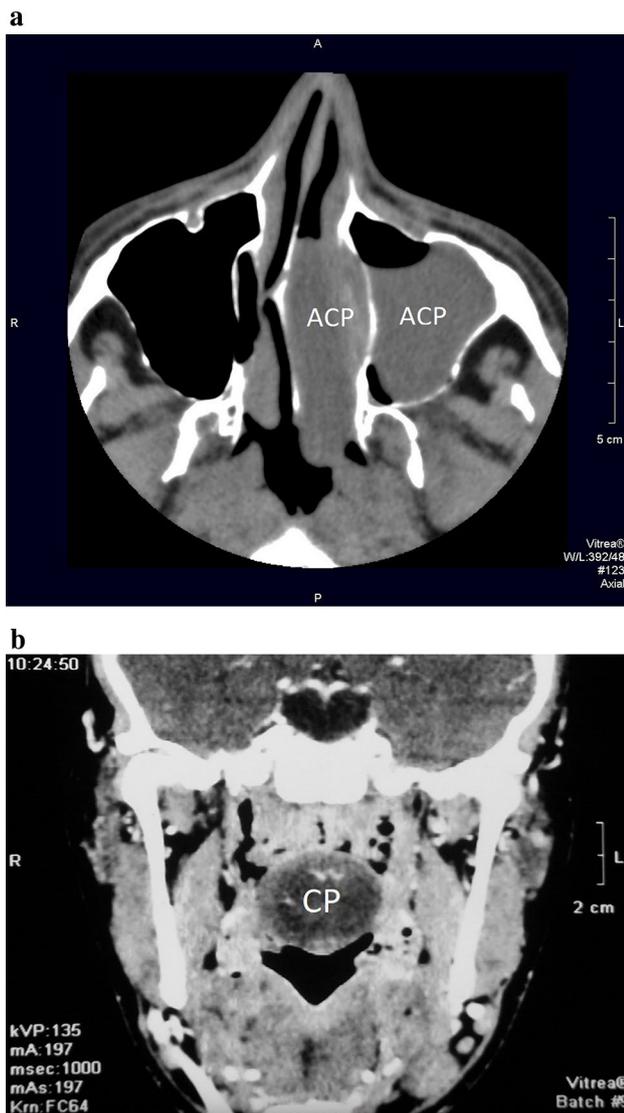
a Axial plane of CT scan of the paranasal sinuses in a 15-year-old boy with ACP. Note the presence of an antral and a nasal portion of the same polyp. b Coronal plane of CT scan on the level of nasopharynx showing an extremely big pharyngeal portion of a CP in a 12-year-old boy
